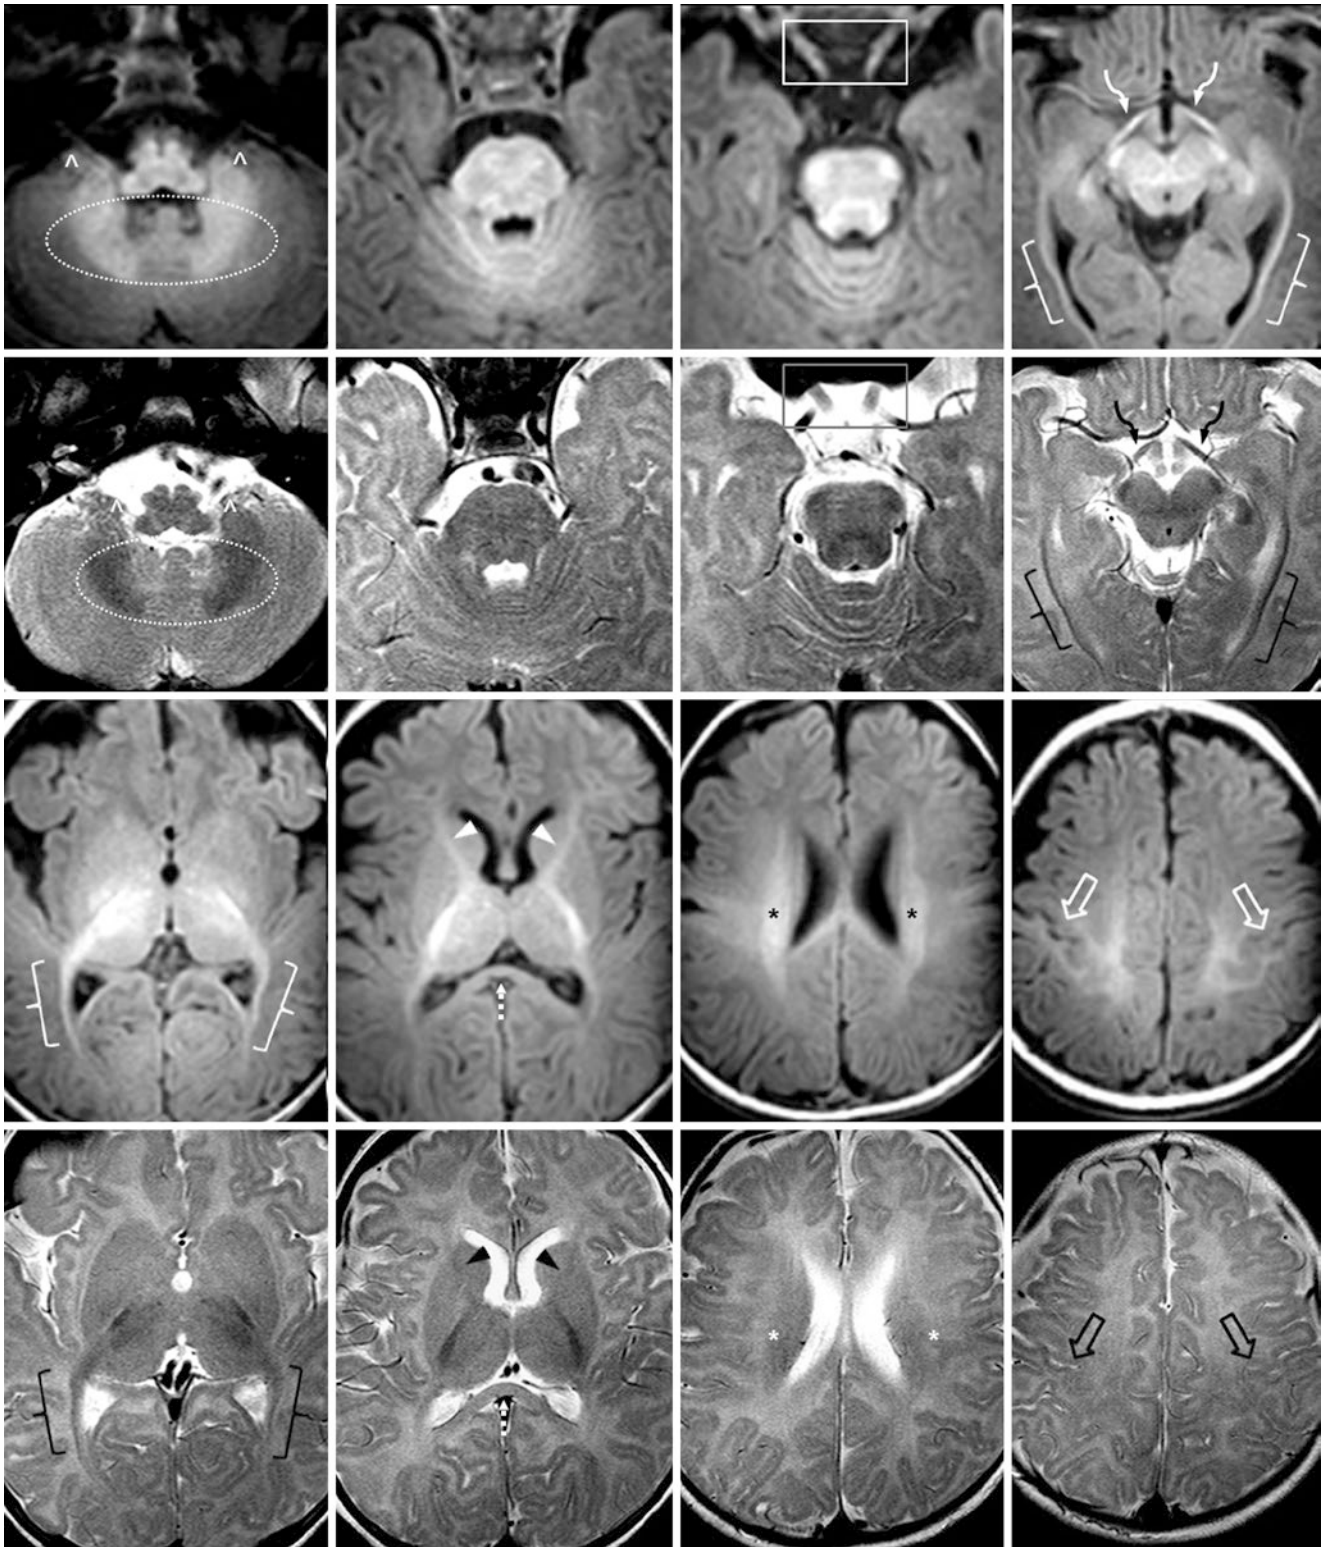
An 11-week-old with questioned trauma, who had a negative 3T MRI, and thereafter developed normally. *Top row:* GE T1WIs depict clear myelination of the cerebellar deep white matter and nodulus (*dotted oval*), and flocculi (*^*). Note myelination of the optic radiations (*brackets*), optic tracts (*curved arrows*), and optic nerves (*box*). *Second row:* SE T2WIs show evident myelination in the same structures noted on GE T1WI. In addition, note that the ventral brainstem is nearly isointense with the dorsal brainstem, and the optic radiations are quite
